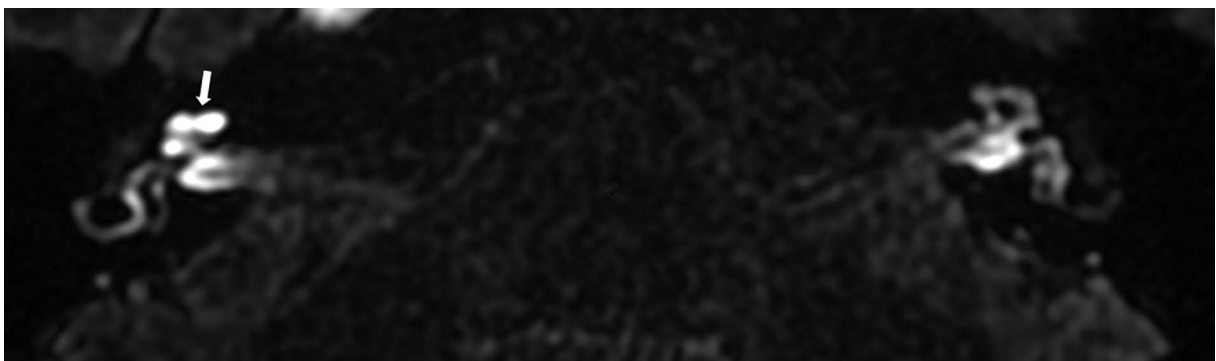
Magnetic resonance images of a 68-year-old male (patient #7) with right-sided clinically defined Ménière's disease. According to the Barath [11] and Bernaerts [13] classification, no signs of cochlear or vestibular endolymphatic hydrops are visible, classified as grade 0 in both scales. Delayed-postcontrast 3D-FLAIR T2 axial image of both ears at the mid-modiolar level revealed a more robust perilymphatic enhancement of cochlea on the affected (right) side (marked with an arrow)
